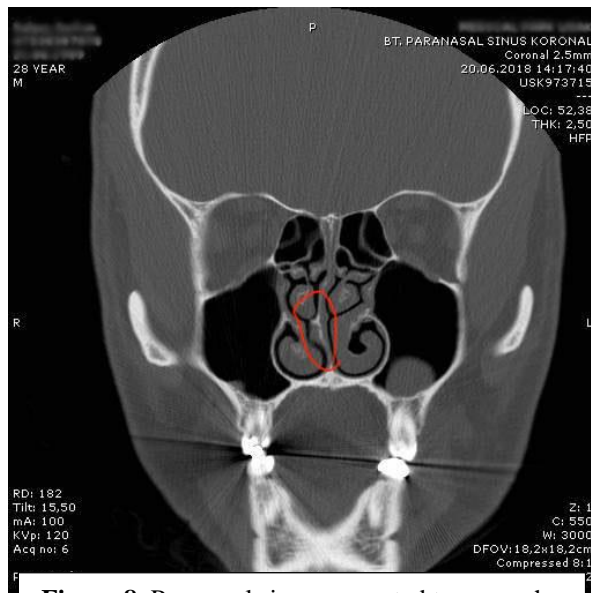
Paranasal sinus computed tomography image of the deviation of the nasal septum to the right.(marked area)
